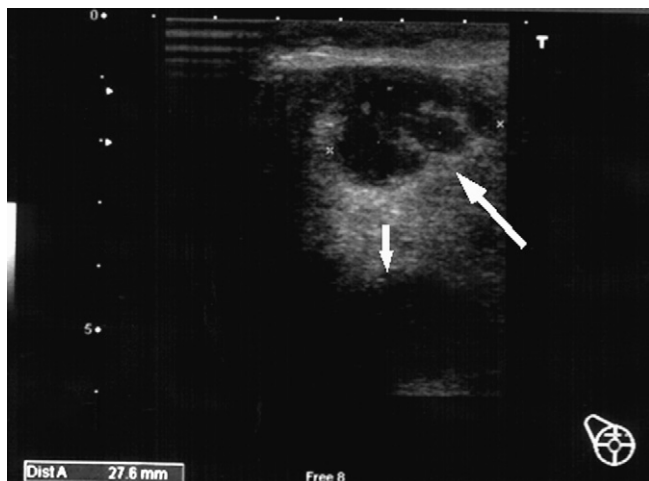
Breast ultrasound: An abscess in width of 2.76 cm (big arrow) and another deeper abscess was beyond the detection of the ultrasound probe (small arrow).
